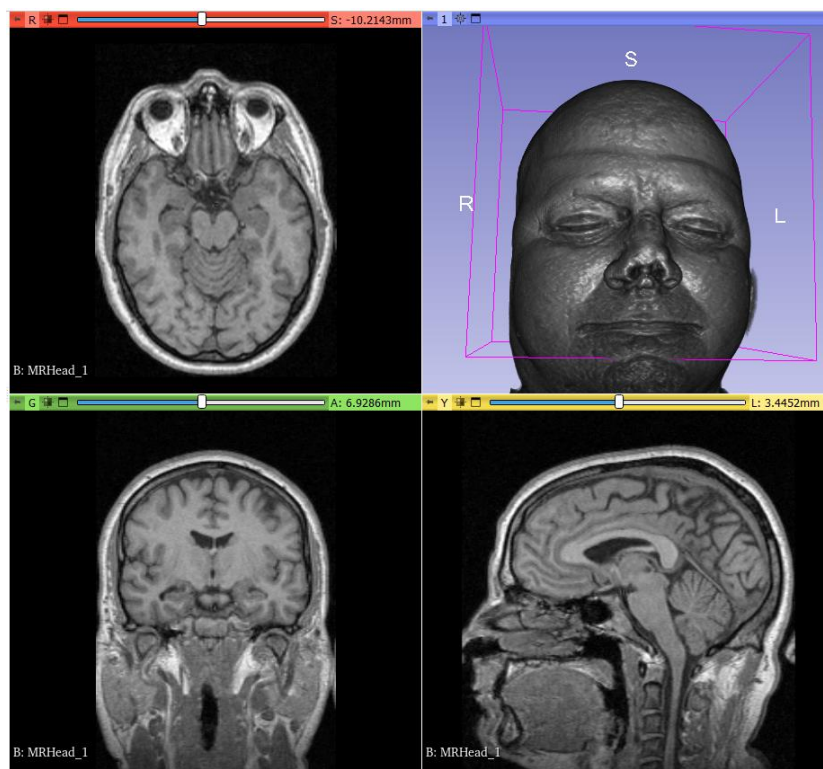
MR image in all three planes (axial, coronal and sagittal)
